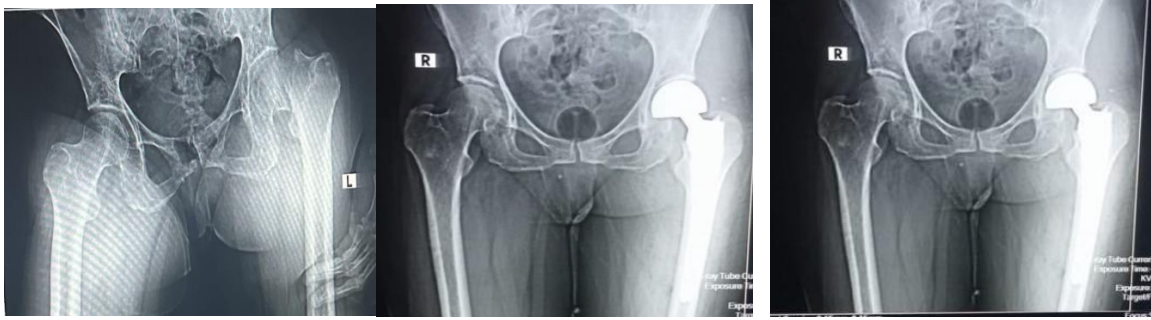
AP hip radiograph of 73 year old patient with fracture right neck femur treated with tripolar total hip arthroplasty
